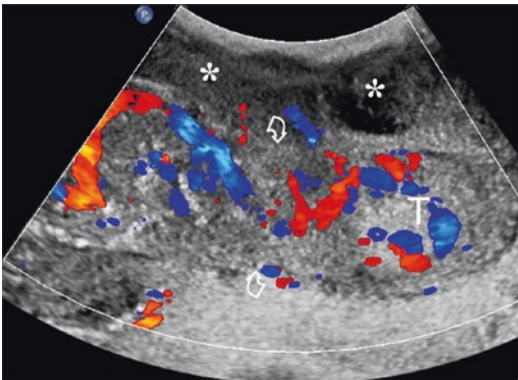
Diffuse large B-cell lymphoma involving the testis and the surrounding tissues. Longitudinal colour Doppler image showing a large infiltrating lesion involving the testis (T), the spermatic cord (curved arrows) and the scrotal wall (asterisk). Note the normal vessels of the spermatic cord running within the tumour mass (arrowheads)
